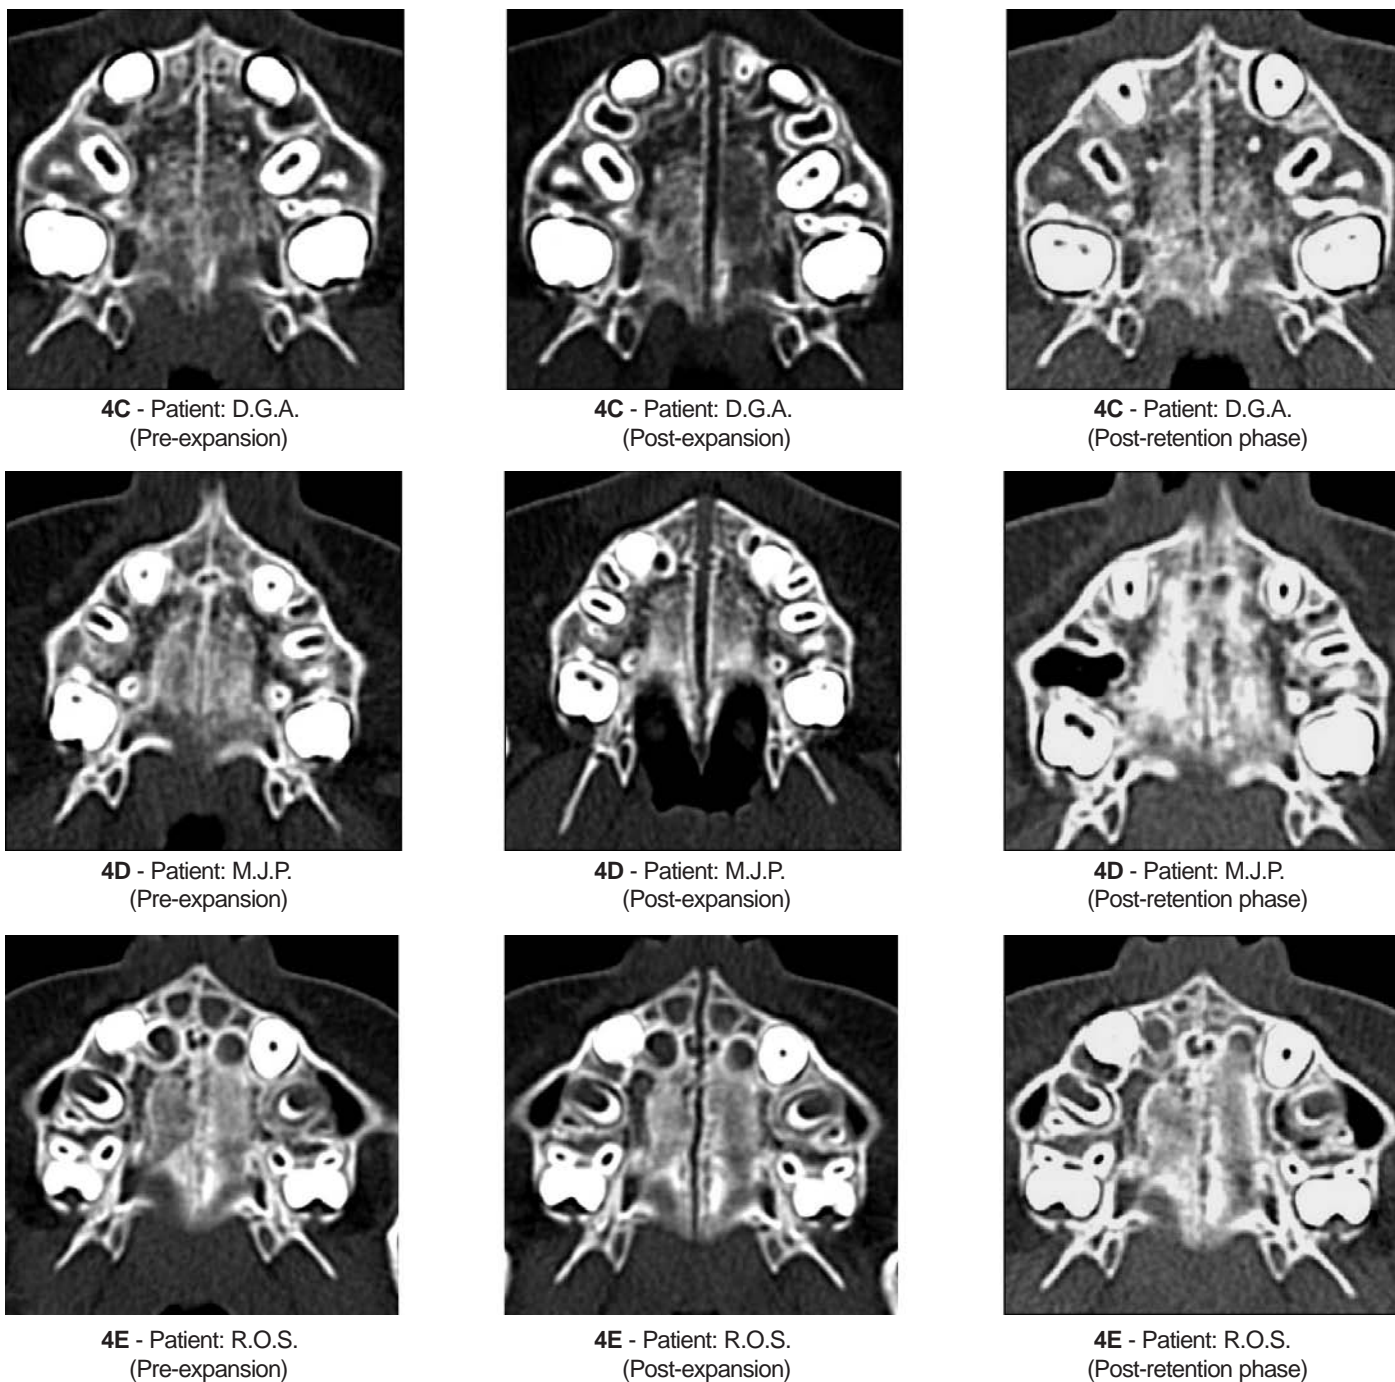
Midpalatal suture image in the pre-, post-expansion and post-retention CT scans (axial scan at the palatal vault level) of 5 of the patients randomly selected from the total sample.
